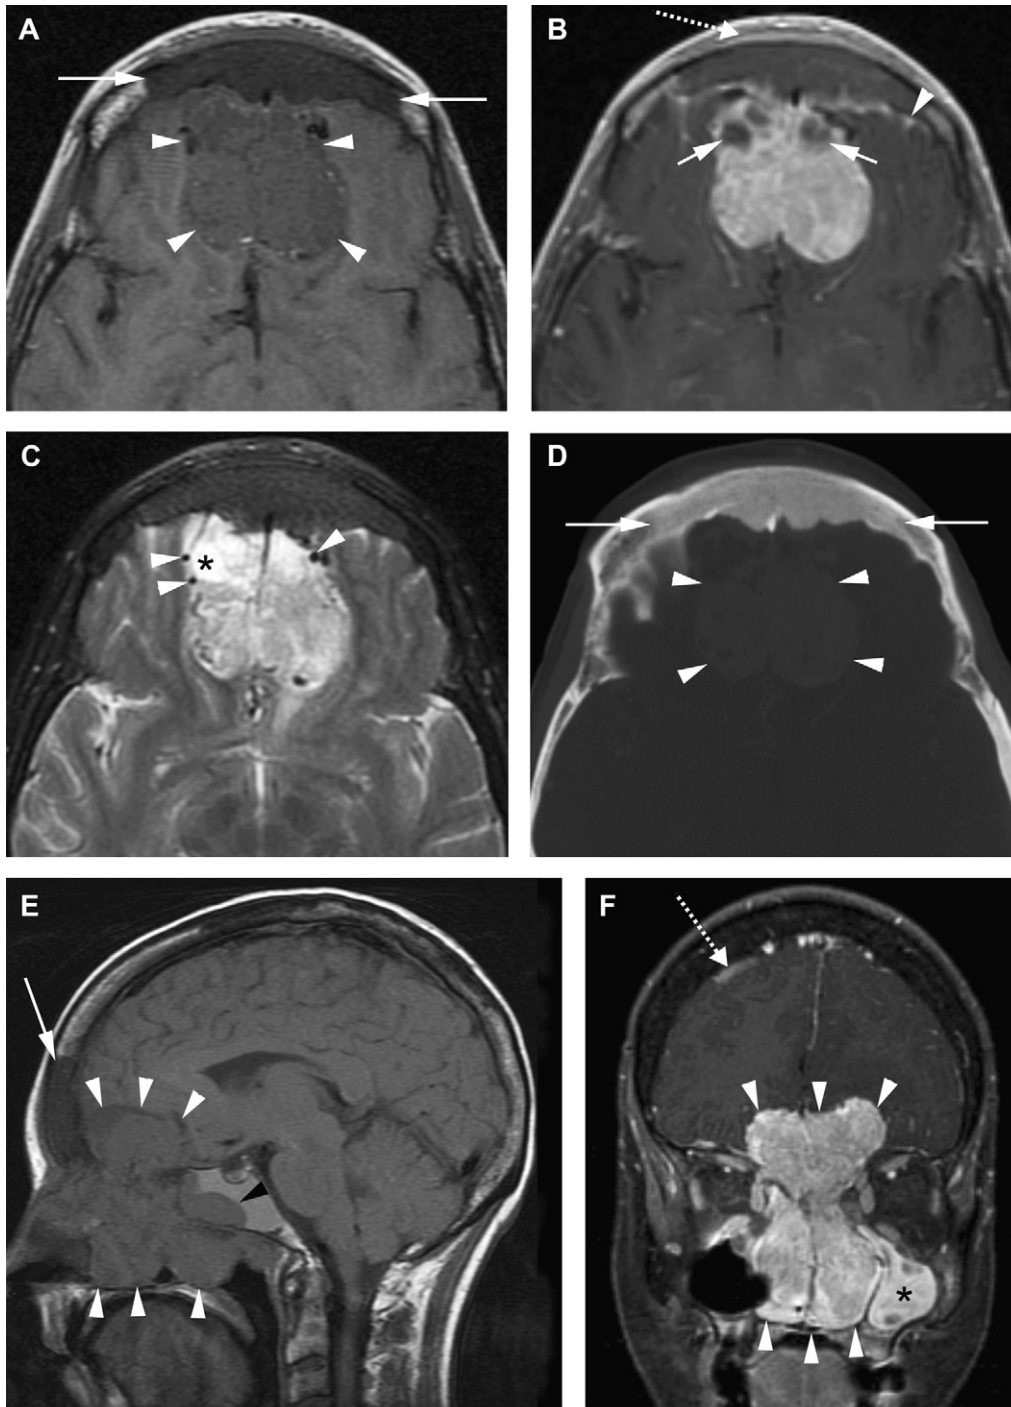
Axial T1-weighted (A) image of the anterior cranial fossa shows an extra-axial, hypointense-to-white matter mass (arrowheads) partially splaying and invading the anterior frontal lobes. There is also a well-circumscribed hypointense lesion replacing and expanding the marrow cavity of the frontal bone (arrows). Axial post-contrast T1-weighted (B) image demonstrates intense enhancement of the mass with non-enhancing cystic structures anteriorly (solid arrows). There is minimal enhancement of the frontal bone lesion. Also note a thin rim of enhancing tissue in the overlying scalp (dotted arrow) and leptomeninges and dura anteriorly (arrowhead). Axial T2-weighted (C) image shows that the mass is heterogeneously hyperintense. Peripheral cystic structures are present anteriorly (asterisk) and flow voids are noted along the periphery (arrowheads). Post-contrast axial CT (D) image through the anterior cranial fossa in bone algorithm shows an enhancing mass (arrowheads) corresponding to that seen on MRI. No calcifications are identified within the lesion. A uniformly dense ground-glass matrix lesion is noted in the frontal bone with smooth bony expansion (arrows). Sagittal T1-weighted (E) image at midline shows the mass within the inferior frontal region extending to the inferior nasal cavity (white arrowheads). The lesion replacing the frontal bone anteriorly (arrow) extends into regions separate from the soft tissue mass. Also note invasion of the sphenoid sinus by the lesion (black arrowhead) with resulting mucous impaction. Coronal post-contrast T1-weighted (F) image shows the extent of the “dumbbell-shaped” enhancing mass (arrowheads) filling the nasal cavity and extending superiorly. The medial wall of the left maxillary sinus is bowed laterally, and enhancing tissue (which is likely post-obstructive) fills the sinus (asterisk). Leptomeningeal or dural metastases are also noted (dotted arrow).
